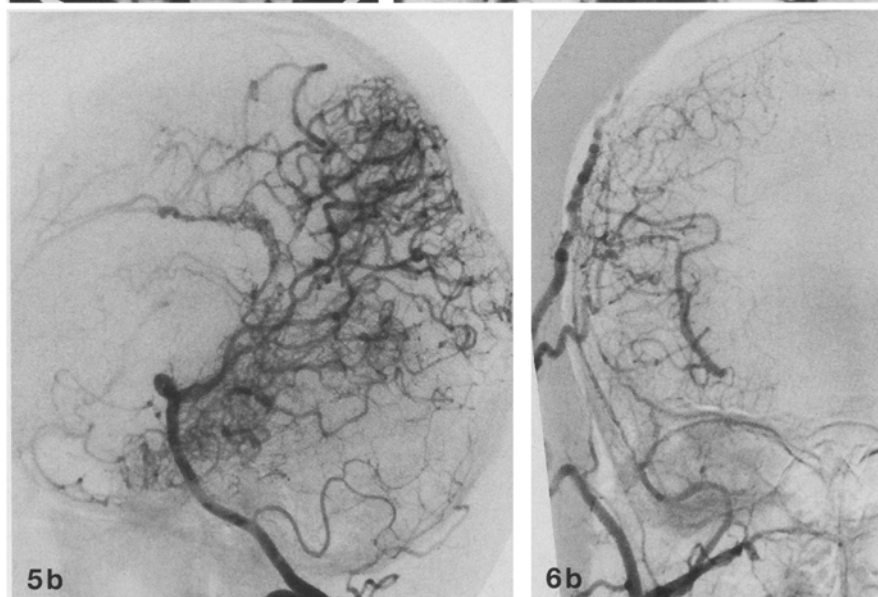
A 20-year-old man who had undergone bypass surgery. a Coronal T1-weighted image shows that both superficial temporal arteries (*arrows*) are markedly enlarged and send transdural collateral vessels. b Right external carotid arteriogram, frontal projection, shows that the superficial temporal artery is markedly enlarged and that the Sylvian branches of the MCA fill via transdural collateral vessels
